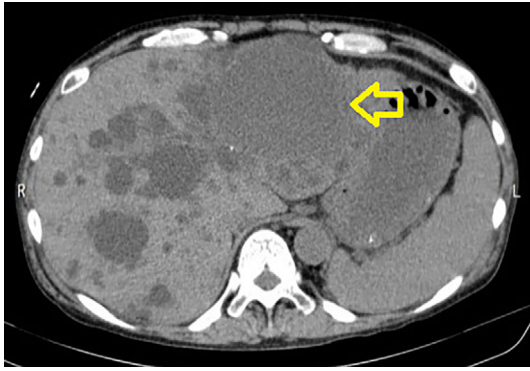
Abdominal computed tomography taken on the day of hospitalization revealed numerous cysts in the liver; however, there was no evidence to indicate a cyst infection arrow: infected cyst.
